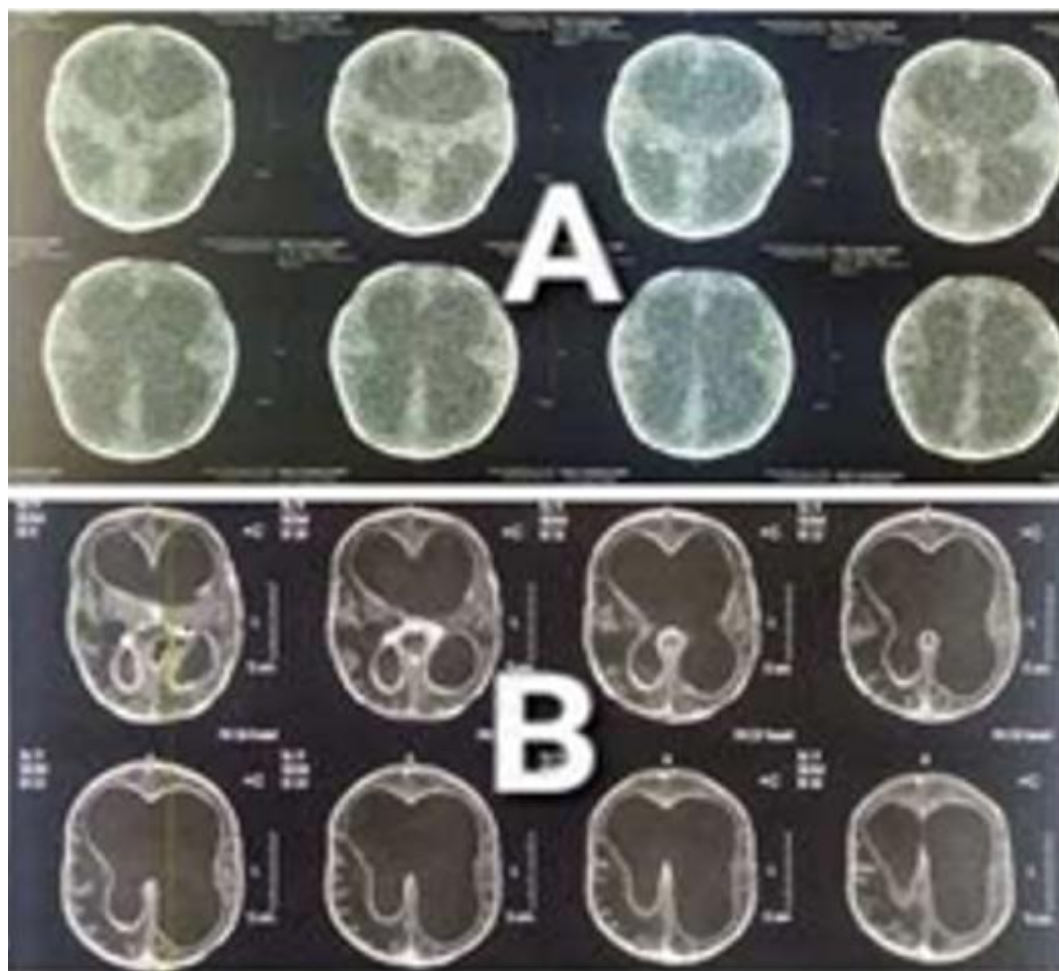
Non-contrast axial images of brain computed tomography where spontaneous hyperdensities are observed in the ventricular hydrocephalus, figure (A) axial view MRI brain with contrast preshow evidence of ventriculitis figure (B).
